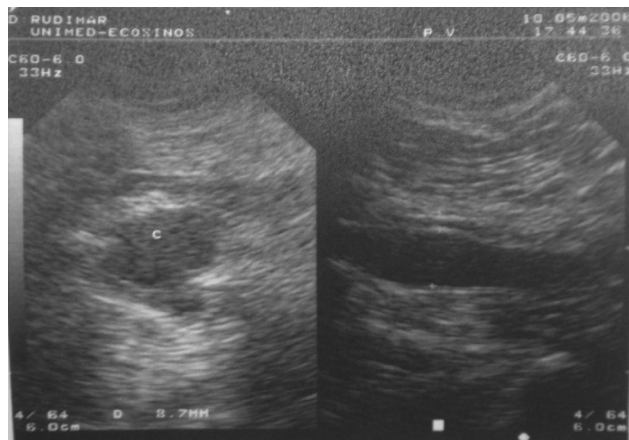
Color-assisted Doppler echography of the right lower limb revealing hypoechoic image compatible with cyst
